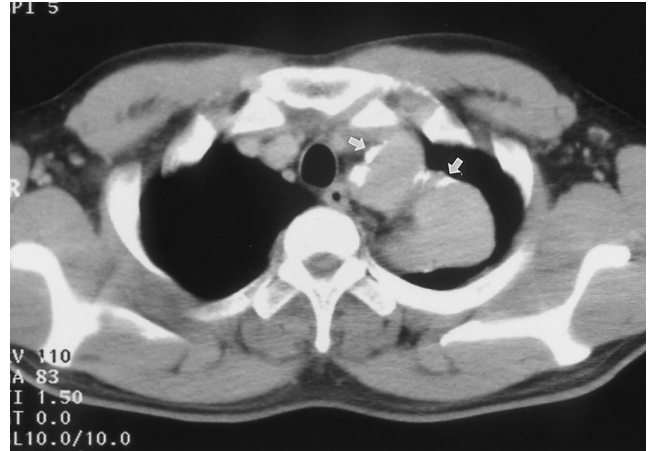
Non-contrast CT shows linear calcifications (arrows) along the dilated aneurysmal wall.
